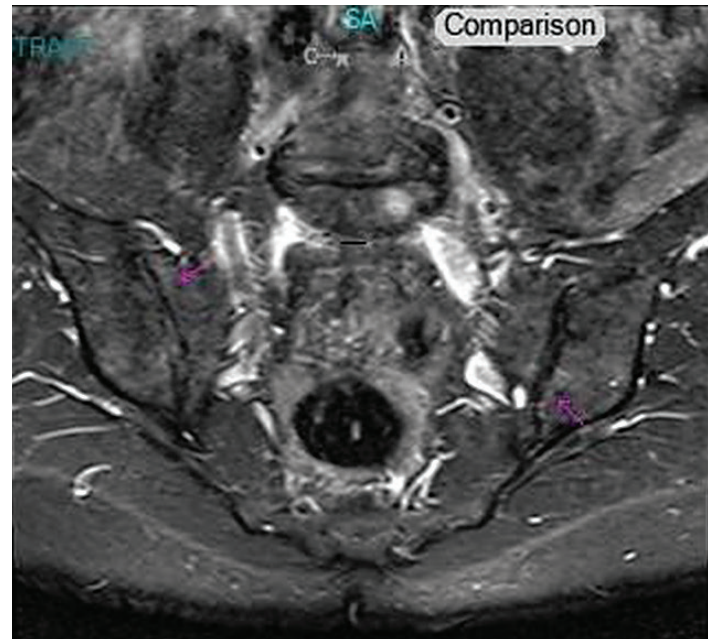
MRI of Case 1 showing bilateral sacroiliitis and minimal osseous edema.
